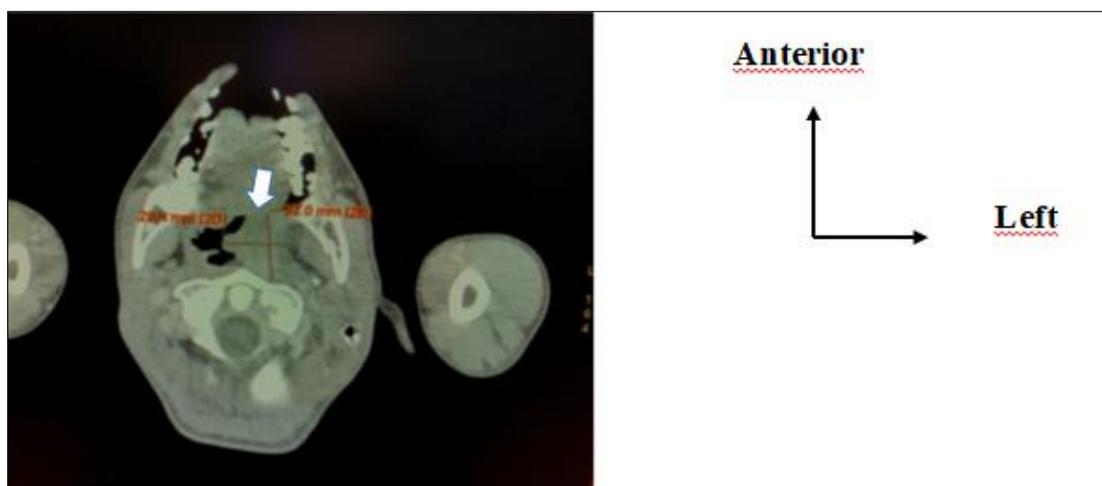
Axial CT +injection section showing irregular thickening of the left lateral wall of the oropharynx responsible for a reduction in the facing lumen
